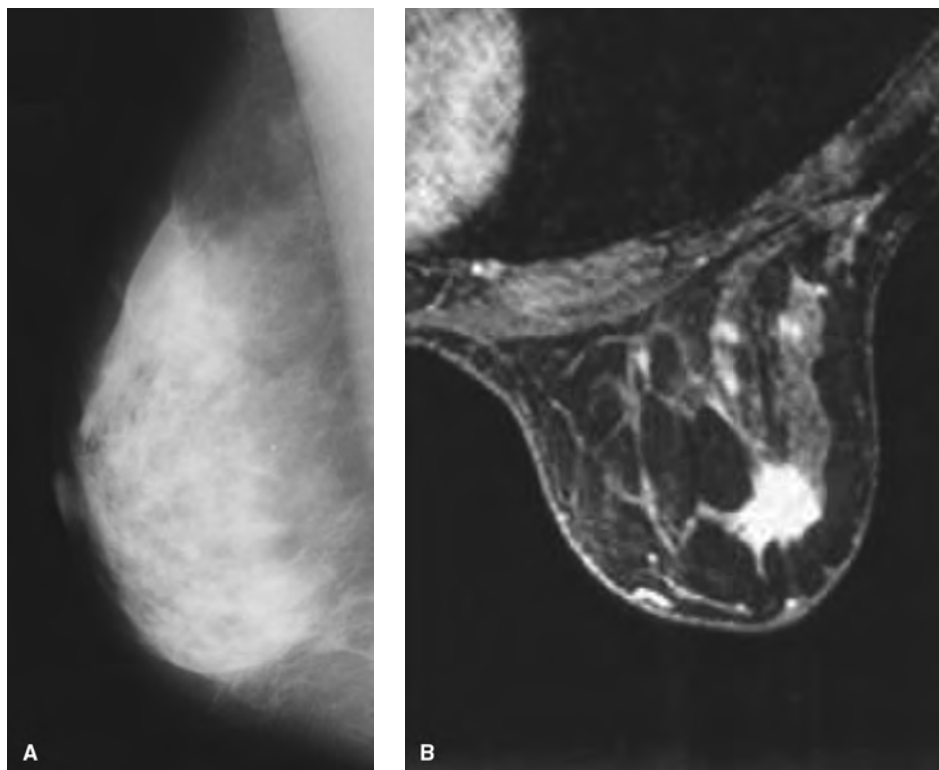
Imaging of an ipsilateral breast tumor recurrence in a patient previously treated with breast conserving surgery and radiation. Given the density of the breast and scar tissue, mammogram was unable to detect recurrence. MRI was more sensitive in discerning density and scar tissue from tumor.
